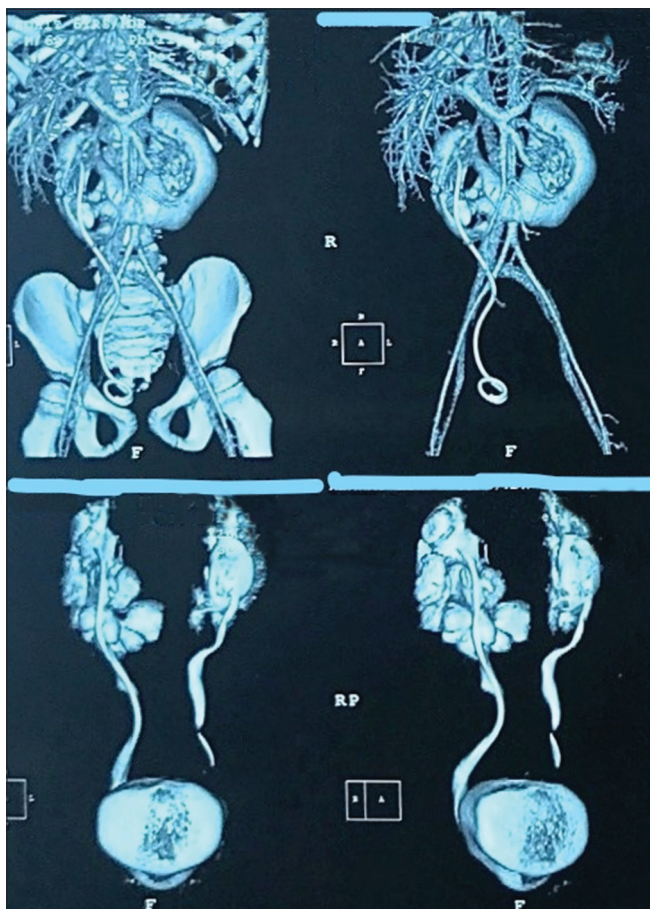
Computed tomography urography with three-dimensional reconstruction
